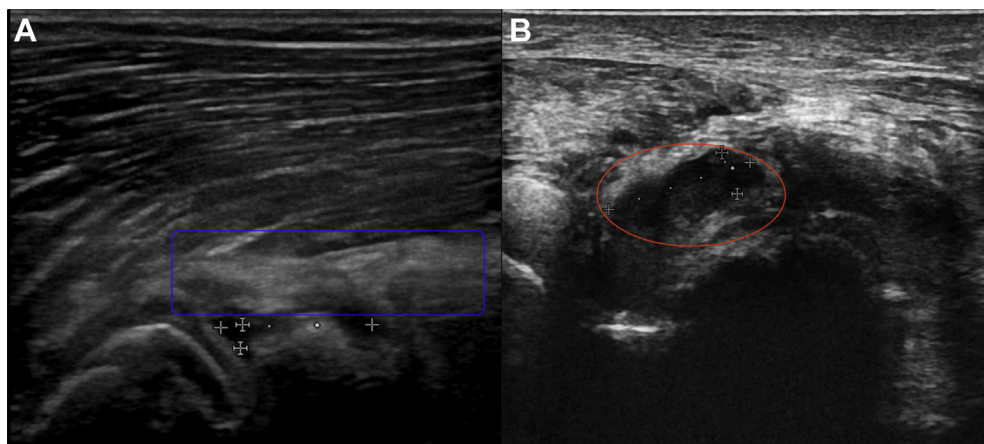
Each patient underwent B-mode ultrasonography with the elbow at 40° flexion after drainage tube removal; the hematoma volume did not differ significantly between the 2 groups. (A) The area of the blue box shows a soft tissue edema. (B) The length, width, and thickness (red circle) of the hematoma and residual exudate on ultrasonography in this patient were 12, 8, and 9 mm, respectively; thus, the volume was about 1 mL.
